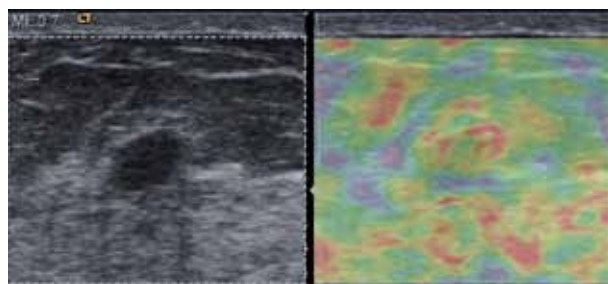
A 41 Year-old Woman with Medullary Carcinoma. Left: On US, the lesion with sonographic features of benign entity in shape, margin, echotexture was classified as BI-RADS category 3. Right: UE revealed the hypoechoic area as a mosaic pattern of green and red (UE 2 Score)
